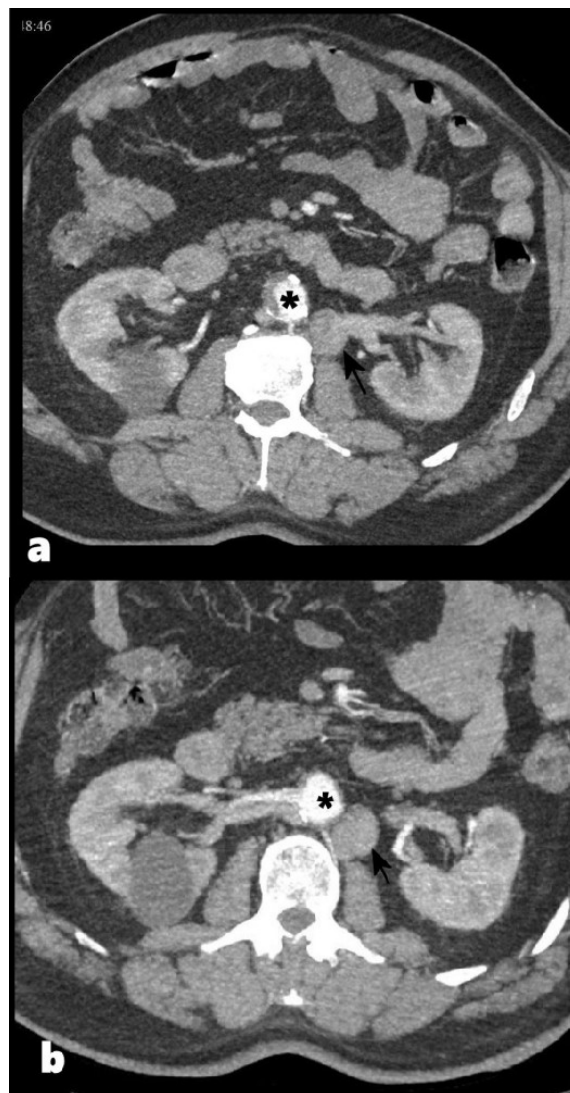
a,b (Thorax CT scan): Left renal vein and right renal vein drains to the vena hemizazyos. *Aorta, → Hemiazygoz
